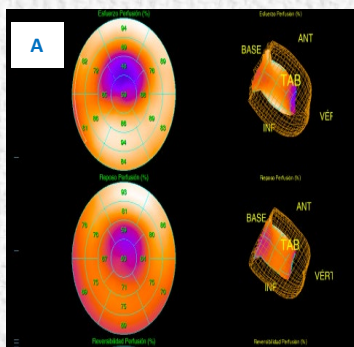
MIBI SPECT showing moderate apical ischemia in stress phase. Figure B Coronary angiography without lesions, except for a fistula of large caliber (2.8 mm of diameter) originating from the left main to the pulmonary artery trunk (No CCTA available)
